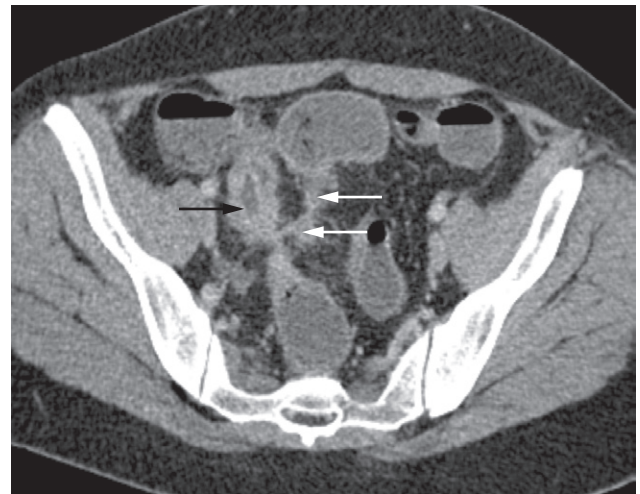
CT of a fistula (white arrows) between the ileum and the sigmoid colon in a patient with Crohn's disease. Note the thickened and inflamed loop of ileum (black arrow).
